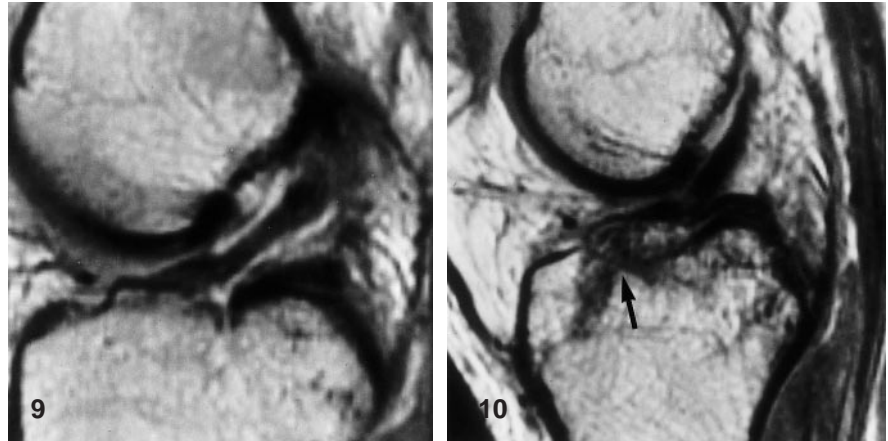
Chronic ACL tear. Sagittal proton density MR image (SE 1800/15) showing a somewhat horizontal course of the ACL. The tear is through the proximal fibers. The ligament is completely surrounded by fluid, does not extend to the wall of the notch, and is probably scarred to the posterior cruciate ligament
